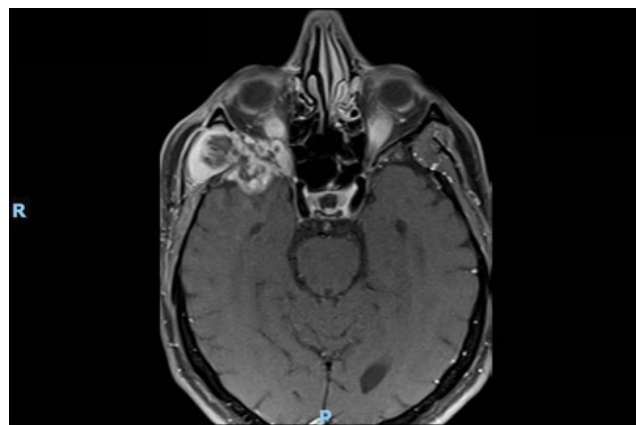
MRI pre-operative axial T1 image.
